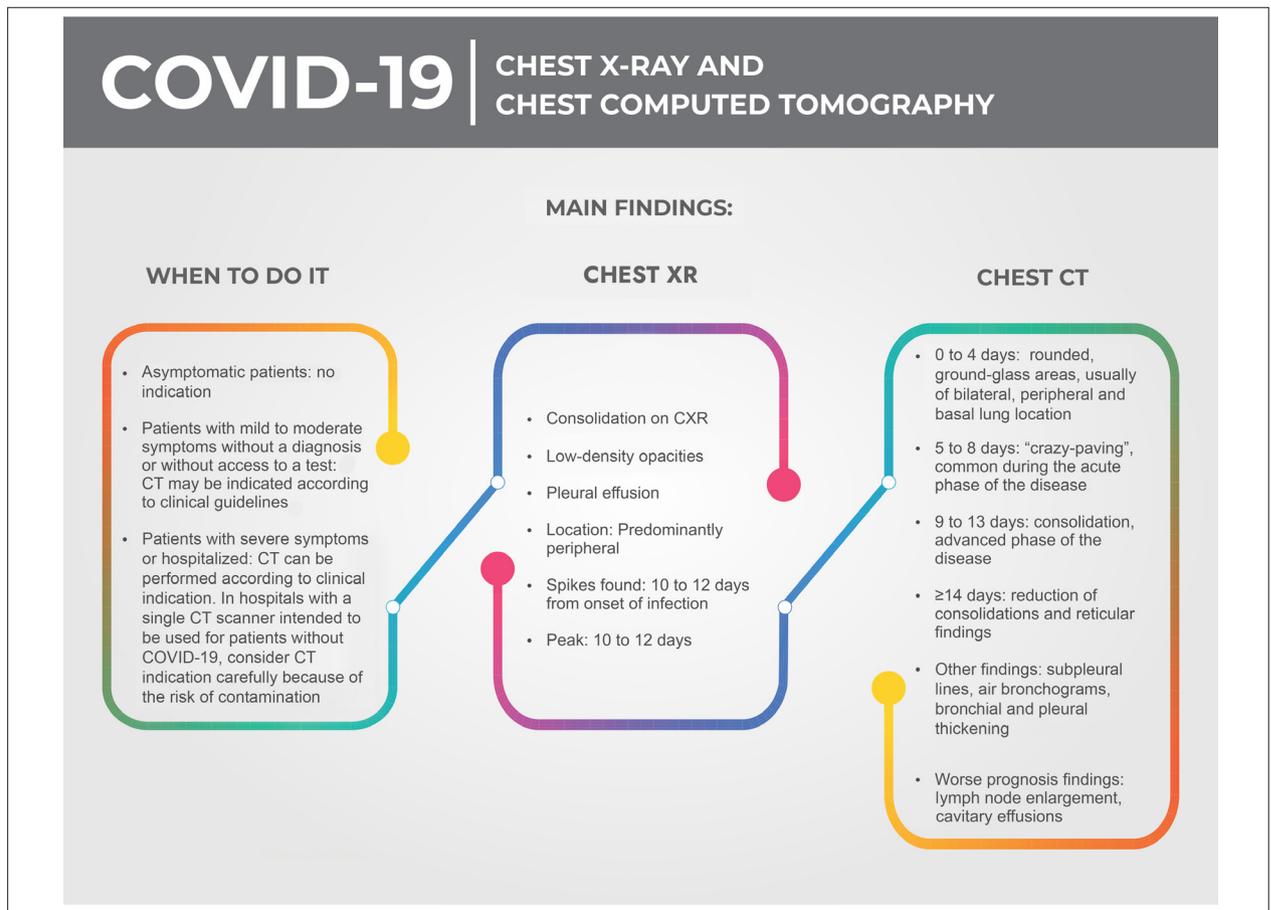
Chest X-ray (XR) and computed tomography (CT) in COVID-19.
